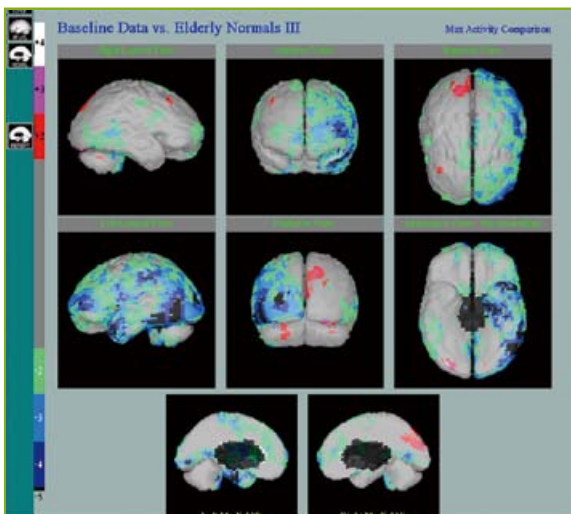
SPECT brain perfusion scan of Ms B (Using the Talairach analysis to compare with normal elderly, which showed unilateral left cerebral moderate hypoperfusion involving Wernicke and Broca areas, occipital and frontal lobes inside which are the speech fasciculi. The right cerebral hemisphere was essentially normal.)
